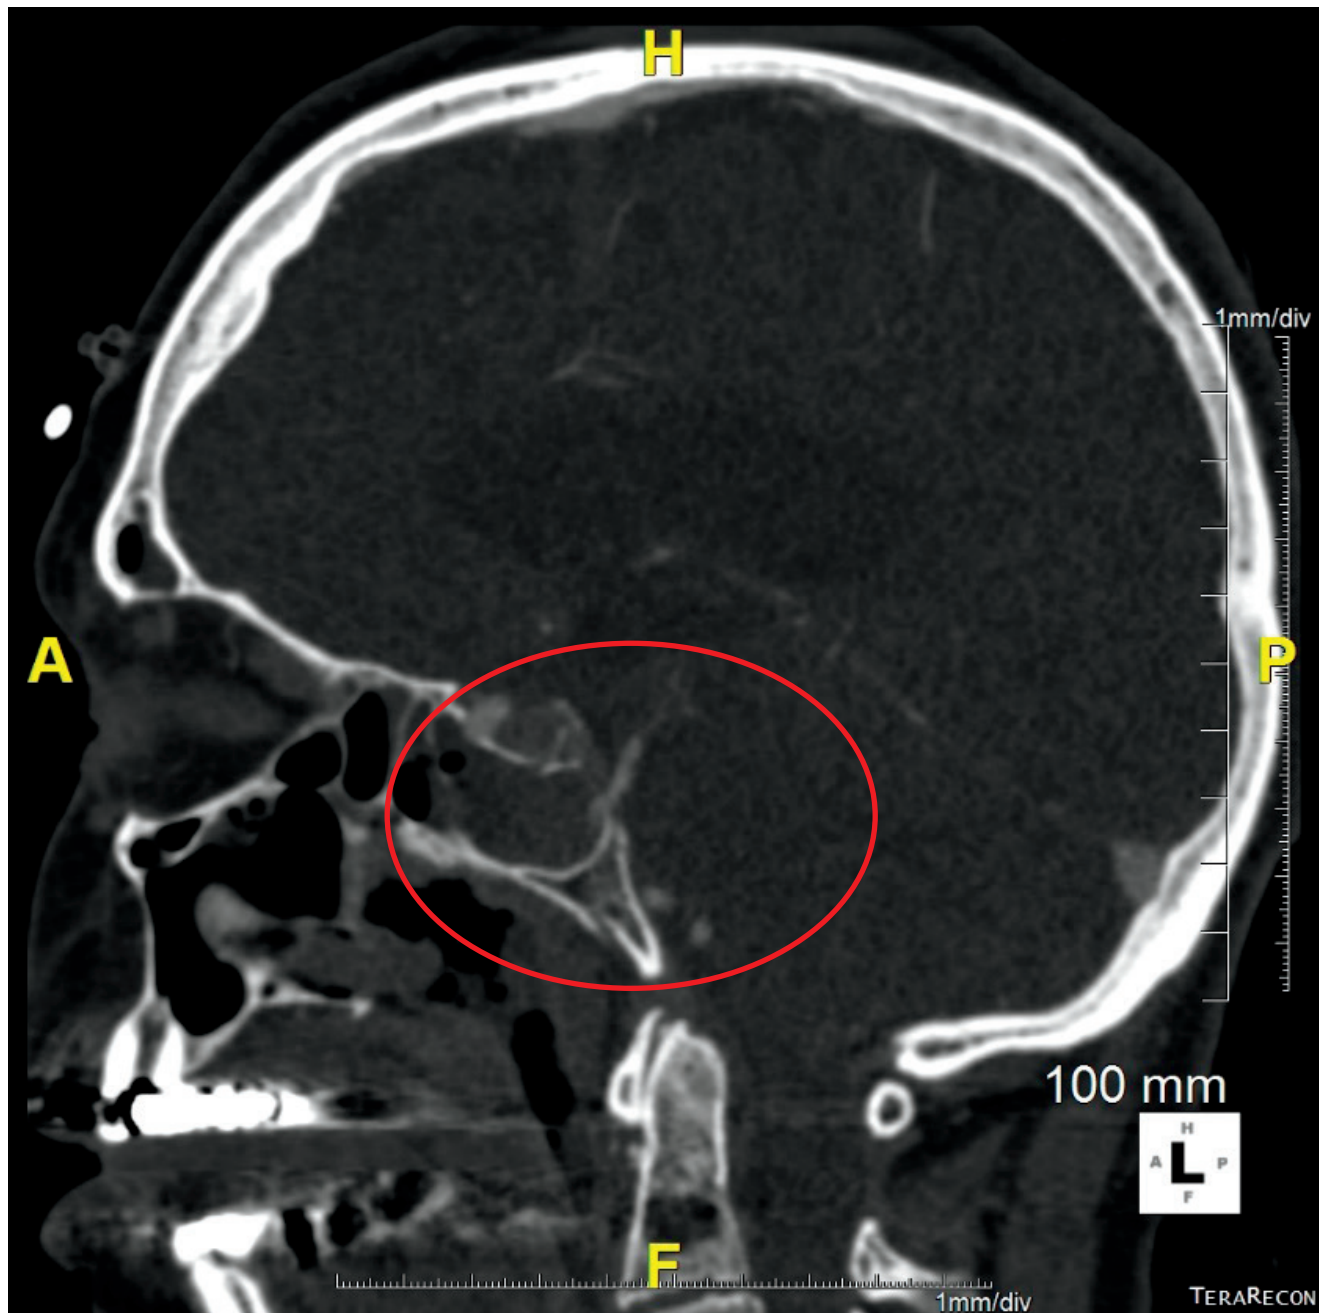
Computed tomography angiogram of the head showing entrapment of the basilar artery in an acute longitudinal fracture of the clivus (sagittal view).
